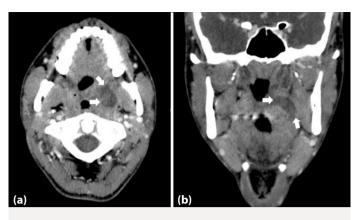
(a) Axial and (b) coronal computed tomography (CT) images showing a peritonsillar abscess.
